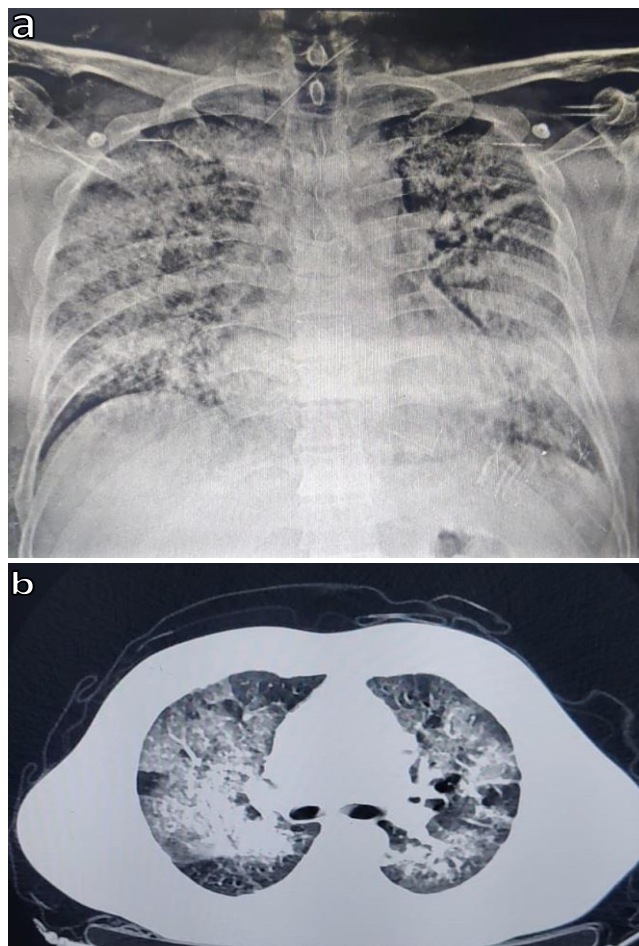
Chest radiograph depicting alveolar infiltrates and ground glass opacity in both lungs (a), CT chest depicting diffuse ground glass opacity of bilateral lungs, patchy consolidation, and nodular septal thickening (b)
